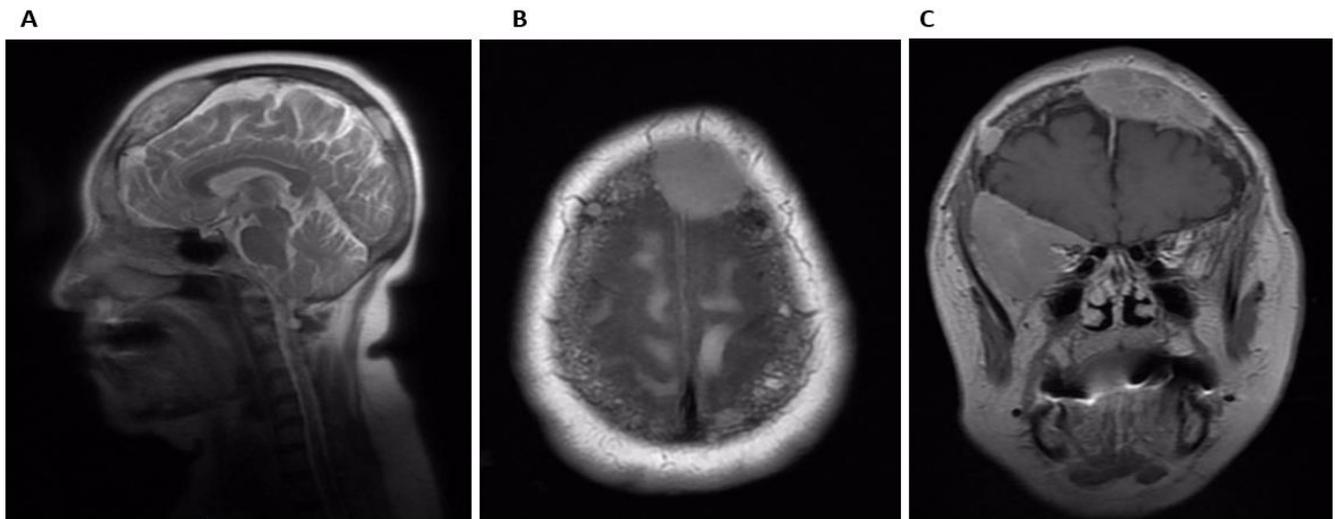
Sagittal (A), axial (B) and coronal (C) MRI showing plasmacytic plasmacytoma and multiple skull plasmacytomas in patient 4, before initiation of myeloma treatment.
